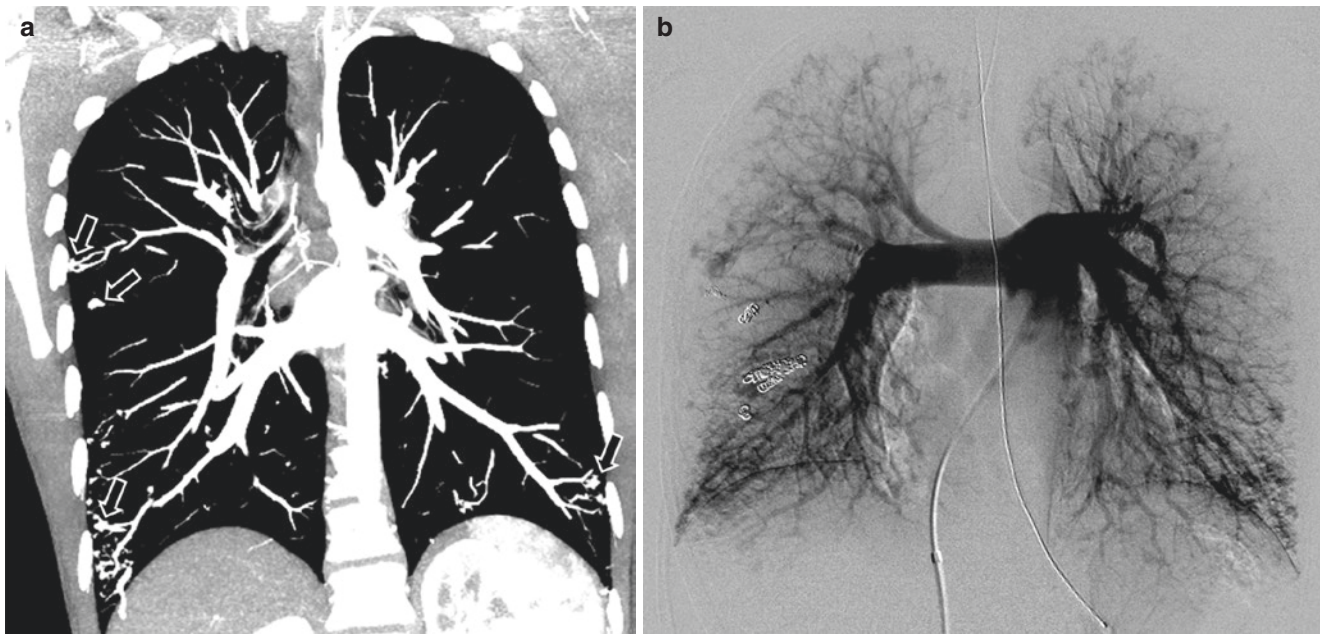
(a, b) A 15-year-old girl with Rendu–Osler–Weber syndrome with multiple small pulmonary arteriovenous malformations. (a) Coronal maximum intensity projection reconstruction of CT image shows multiple small pulmonary arteriovenous malformations (AVMs).
